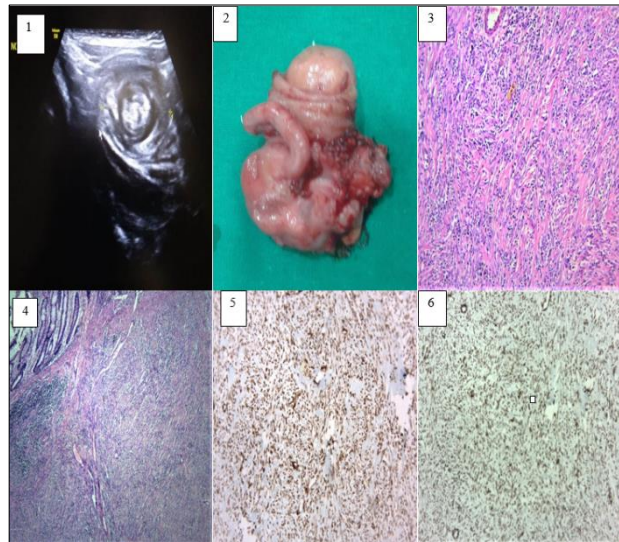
1) Ultrasonography showed the target sign.
